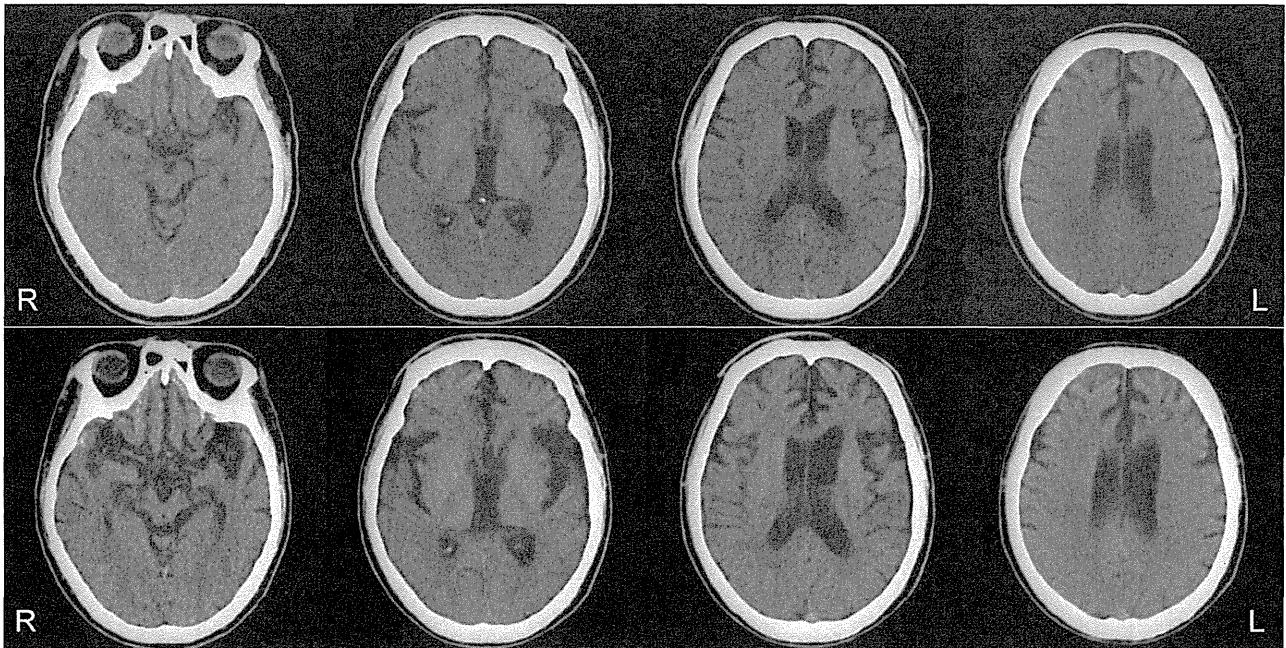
Brain computed tomography scan images in a CBD-M case (case 9) that was clinically diagnosed with PSP 4 years (the upper layer) and 5 years after onset (the lower layer). Left side-predominant frontotemporal atrophy and dilation of the third ventricle are seen. Cortical atrophy is more severe in the frontal lobes than in the temporal lobes. The midbrain was also evidently atrophic (the lower layer). CBD-M, corticobasal degeneration initially showing motor symptoms as initial symptoms; L, left; PSP, progressive supranuclear palsy; R, right.
